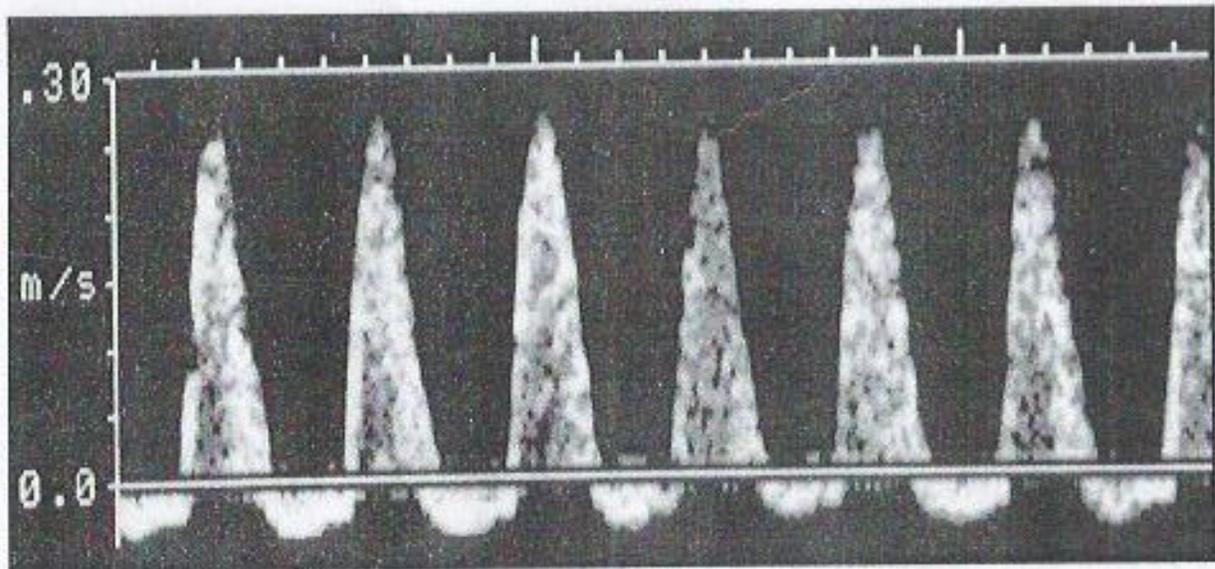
Doppler velocimetry demonstrating reversed diastolic flow. (Courtesy of Dr. Diane Twickler.)
